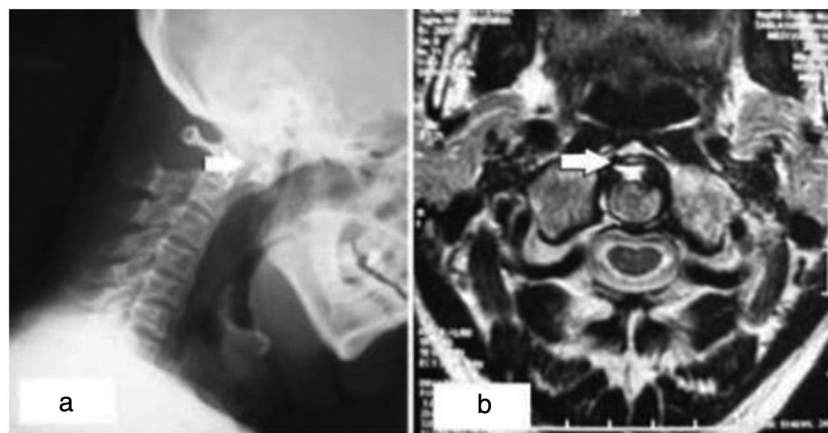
(a) Lateral X-ray of the cervical spine in hyperflexion showing a C1–C2 diastasis. (b) Axial section of MRI showing C1–C2 arthritis, the presence of an edematous pannus, atlantoaxial subluxation.
